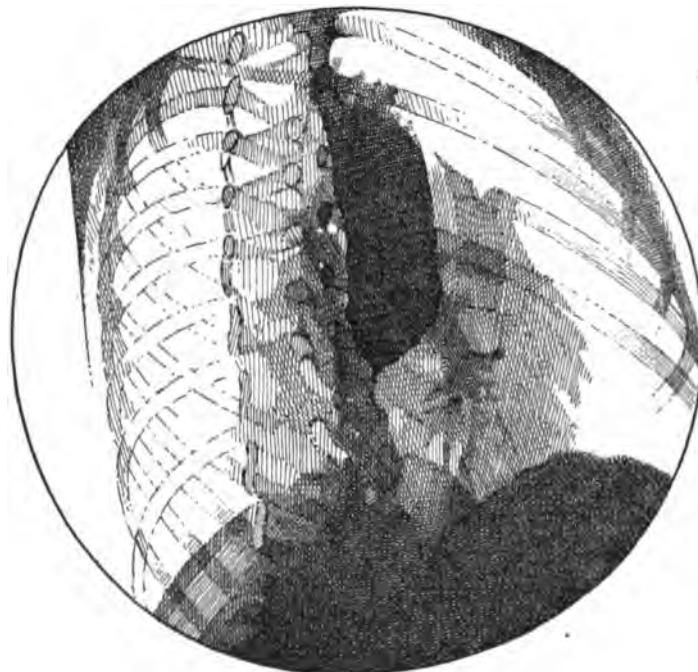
RADIOGRAPH FROM A CHILD OF 8 YEARS WITH A CONGENITAL STRICTURE OF THE ESOPHAGUS.
